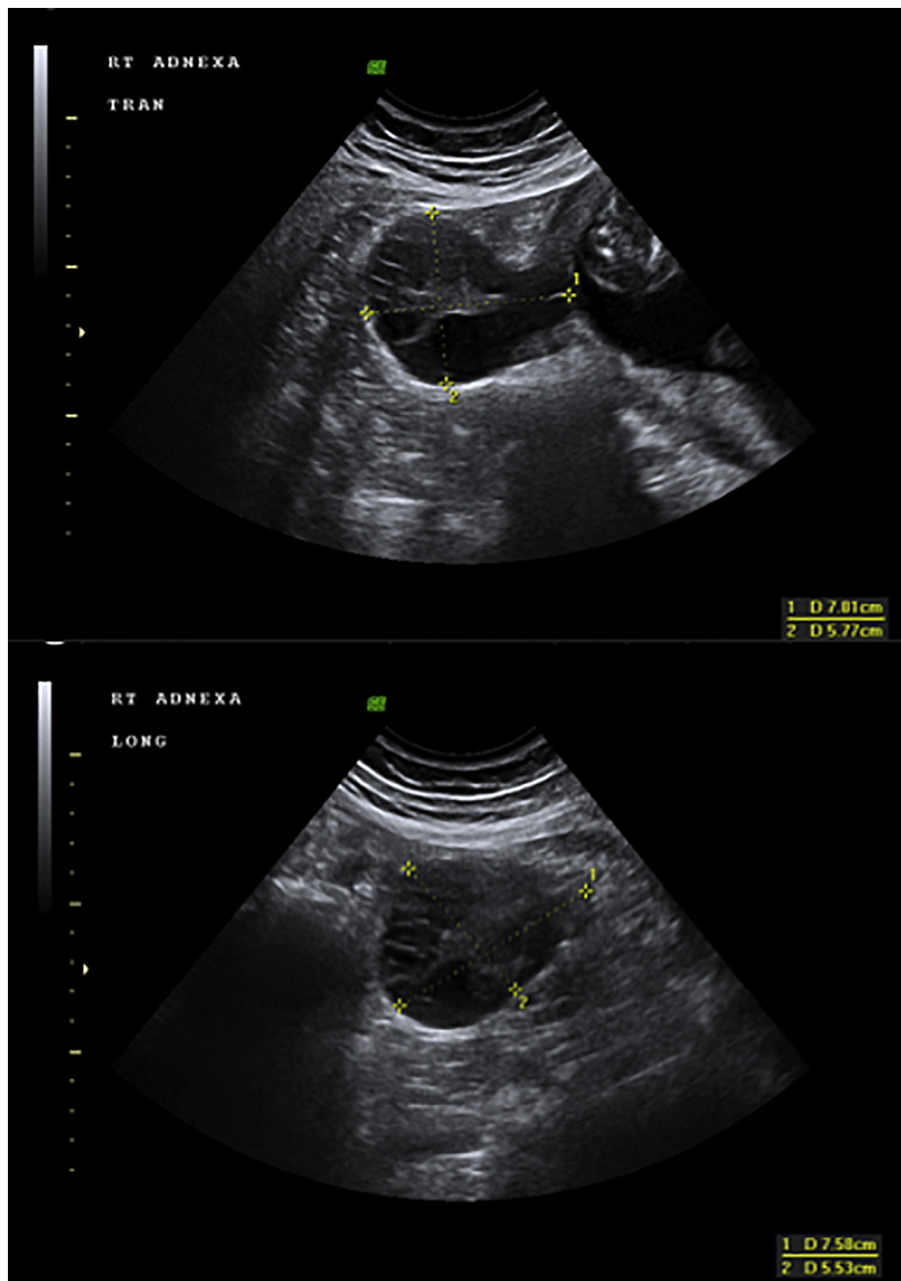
Ultrasound scan of the right ovary at 18 weeks' gestation. Upper image: Transverse plane. Lower Image: Longitudinal plane.
